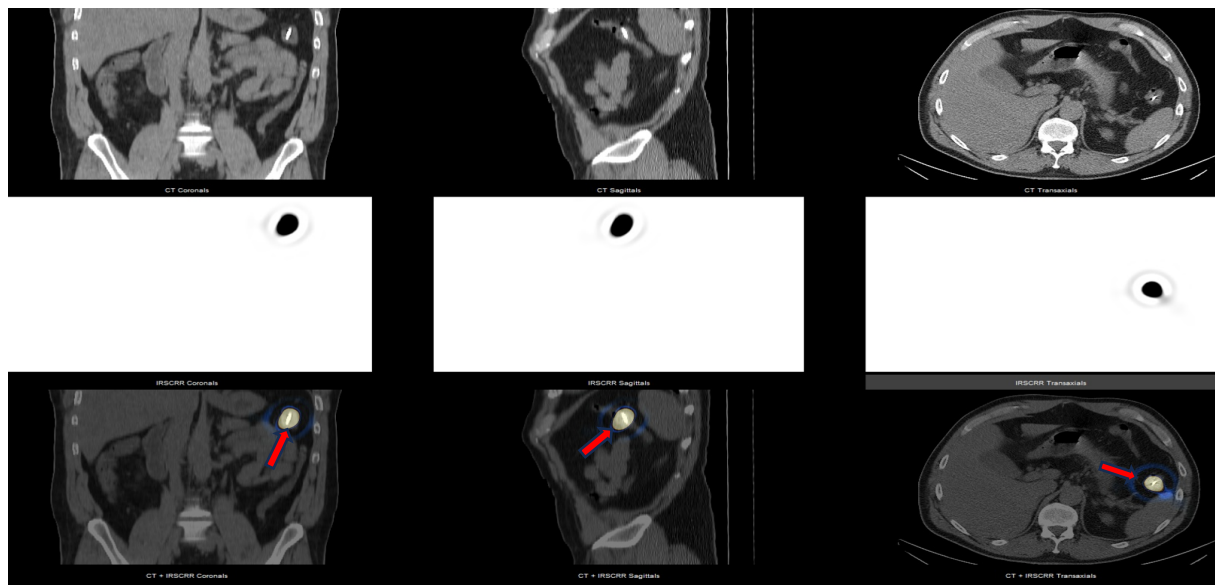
Planar and SPECT-CT imaging over coronal, sagittal and axial planes that only depict focal radioactivity at the SF injection site (red arrow).
